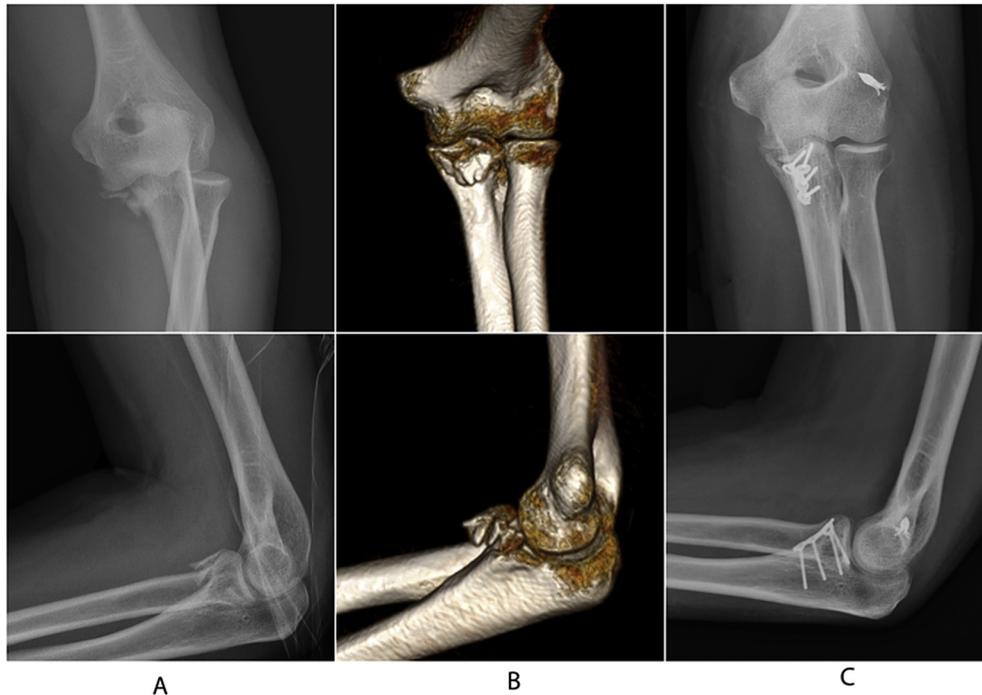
Radiographs (A) and CT scans (B) of a comminuted coronoid fracture. Fixation with an anterior buttress plate and screws (C). Figure used with permission from McGuire G, Bain GI. Medial and lateral collateral ligament repair or reconstruction of the elbow. *Oper Tech Orthop.* 2013;23:205–214.
